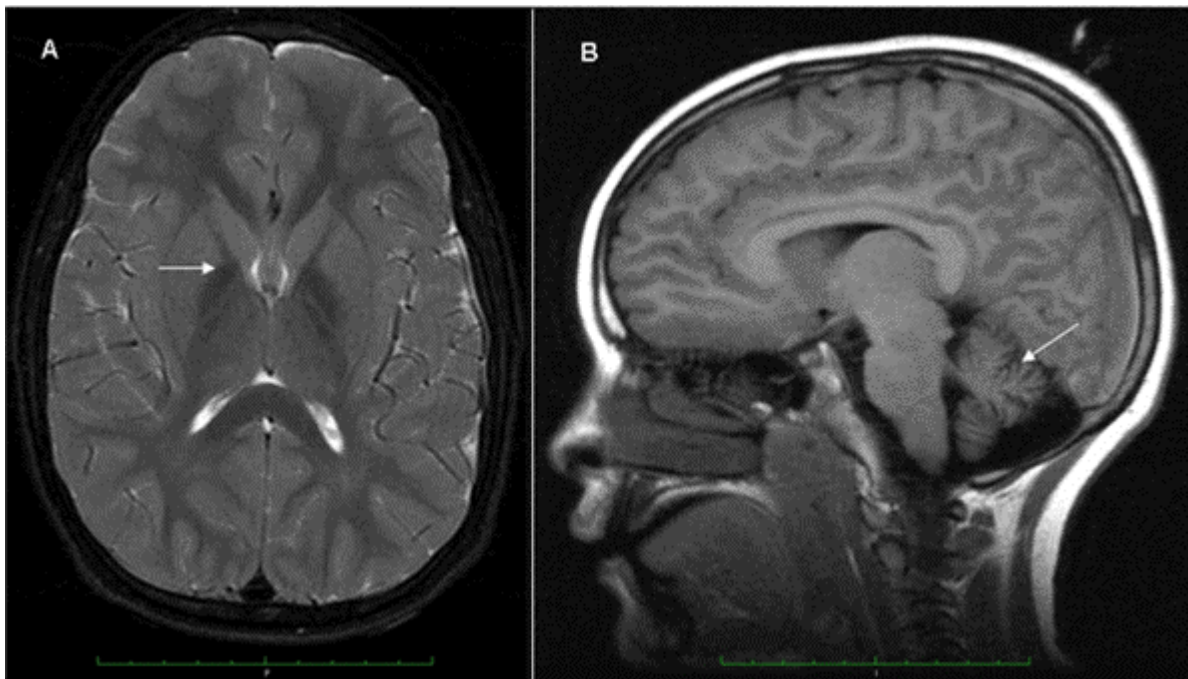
A. Left axial image shows high brain iron in the globus pallidus (see arrow) on T₂-weighted MRI. B. Right sagittal image shows cerebellar atrophy (see arrow).
